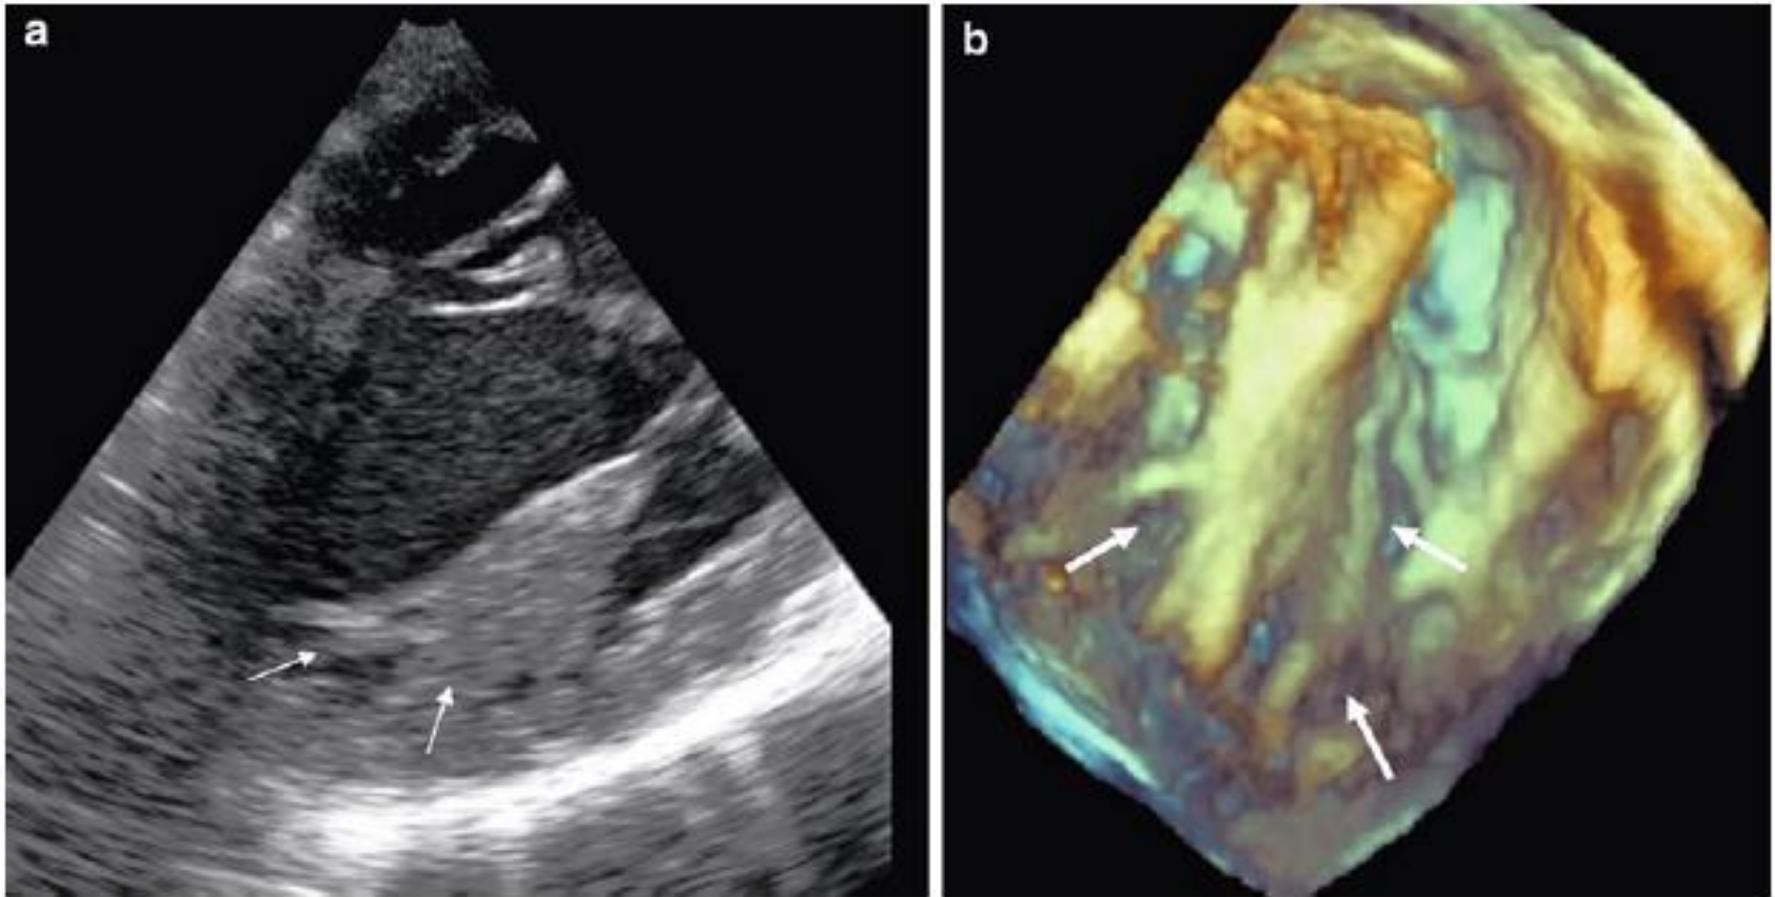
a Transesophageal and transgastric two-dimensional image and (b) three-dimensional echocardiographic view of the same patient in a similar
